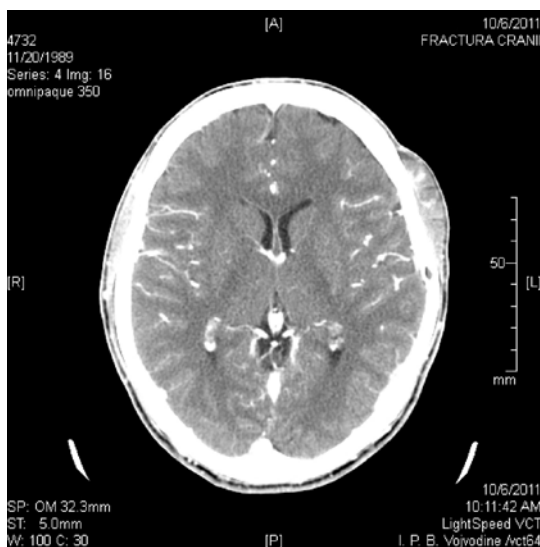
Computed tomography showing in isointense soft tissue mass.
